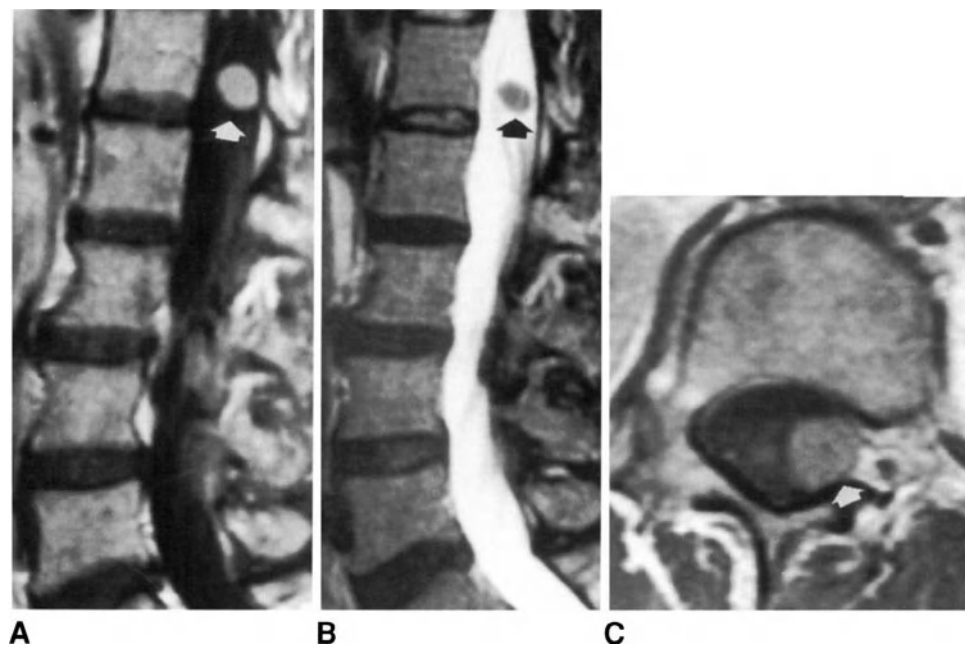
MR images of intrathecal neurinoma at L1 level. (A) Sagittal T1-weighted spin-echo image after administration of gadolinium. (B) Sagittal turbo T2-weighted image. (C) Axial T1-weighted spin-echo image after injection of gadolinium. A roundish lesion, showing a homogeneous increase in signal intensity, is visible within the thecal sac after administration of contrast medium. On the T2-weighted image, the lesion can be clearly differentiated from the CSF due to its lower signal intensity.
